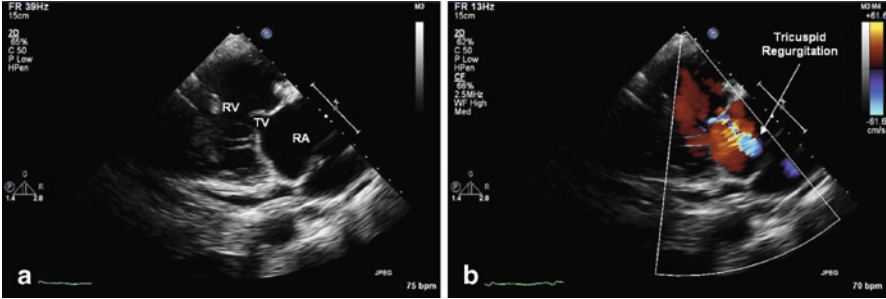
Right ventricular inflow (RVIF) view. The RVIF view is obtained by tilting the transducer toward the left shoulder so the ultrasound beam moves anterior in the chest slicing through the right heart. (a) This view is used to assess the right ventricle, tricuspid valve, and right atrium. (b) Color flow and spectral Doppler are used to assess the valve for tricuspid regurgitation
